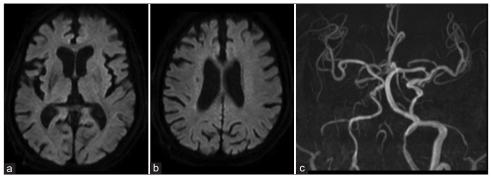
Postoperative magnetic resonance imaging, (a and b) diffusion-weighted image , and (c) magnetic resonance angiography showing no infarcts and improvement in the right cervical internal carotid artery stenosis.
